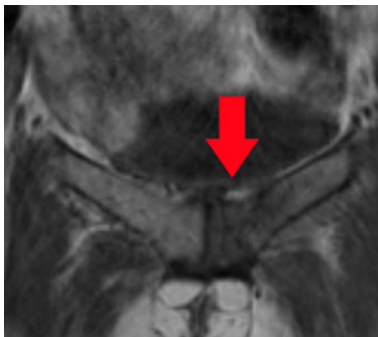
T1 weighted MRI in a coronal orientation showing a lesion in the left pubic body (red arrow) suggesting fracture.
